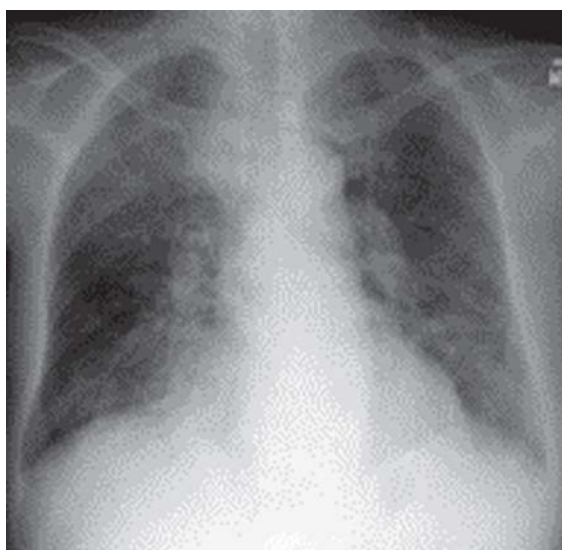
A chest X-ray of the patient with abnormalities in the lung¹⁹
